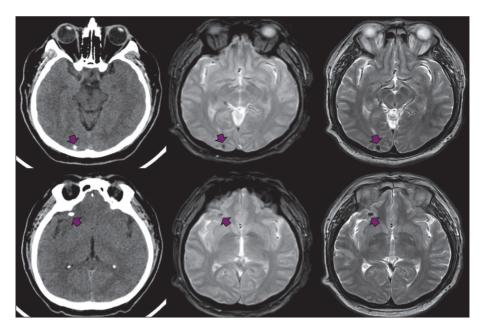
Unenhanced CT scans showing parenchymal brain calcified cysticerci located in the right temporal and occipital lobes from one subject (left panel). On MRI, these lesions appear as signal void lesions in both gradient-echo (686/23) and T2-weighted (4500/100) sequences (center and right panels, respectively).
